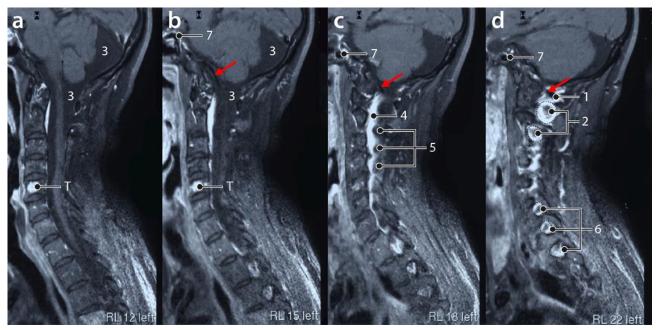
Sagittal post-gadolinium contrast enhanced fat-suppressed MRI adjacent slices (thickness 3 mm) of a patient with a tumor (T) in the vertebral column. This series present the mid-sagittal slice (5A) up to the slice through the left neuroforamina (5D). In slice 5D a cross-section of the vertebral artery in the vertebral sulcus of the atlas is imaged (1), as also indicated by a red arrow in 5D and at the ventral side of the pons in 5C and 5B. The artery in 5D (hypointense) is surrounded by a venous plexus (hyperintense). This venous plexus shows contrast enhancement, because blood flow in this plexus is almost absent and the gadolinium in this plexus is still present in this post-injection phase as well as in the tumor (T in 5A & 5B). Also, the hypointense spinal nerves in the neuroforamina are surrounded by hyperintense enhancing veins (2 & 6). These neuroforaminal veins are circled by dashed lines. In slice 5C presents the large longitudinal veins of the IVVP (4) with the spinal ganglia (5) as hypointense indentations dorsal to the enhancing IVVP. In 5D the hypointense spinal nerves C7, C8 and Th1 are visible (6) surrounded by hyperintense neuroforaminal veins. More dorsally, the chain of zygapophysial joints is present. The internal carotid artery is also visible in 5B, 5C and 5D (7).
